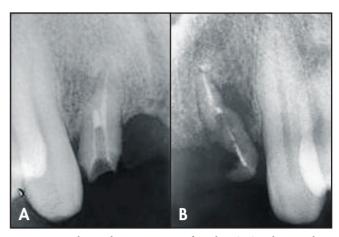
Radiographic appearance of tooth #7(12) with vertical root fracture. 2B. Preoperative radiograph of endodontic failure of tooth #10(22).
